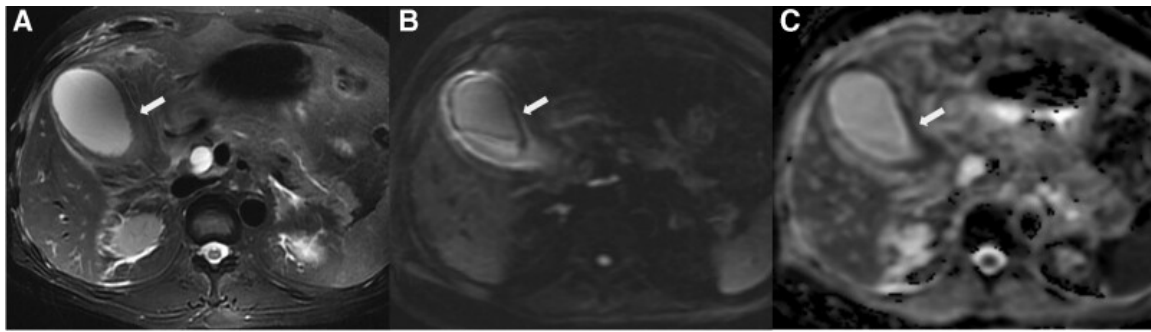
(a-c): Acute gangrenous cholecystitis in a 53-year-old male, (a) T2WI fat-sat shows diffuse wall without hypointensity layering, with papillary change from mucosal irregularity, (b) DWI demonstrates diffuse hyperintensity with layered pattern, (c) ADC map shows corresponding layered hypointensity in the gallbladder neck
